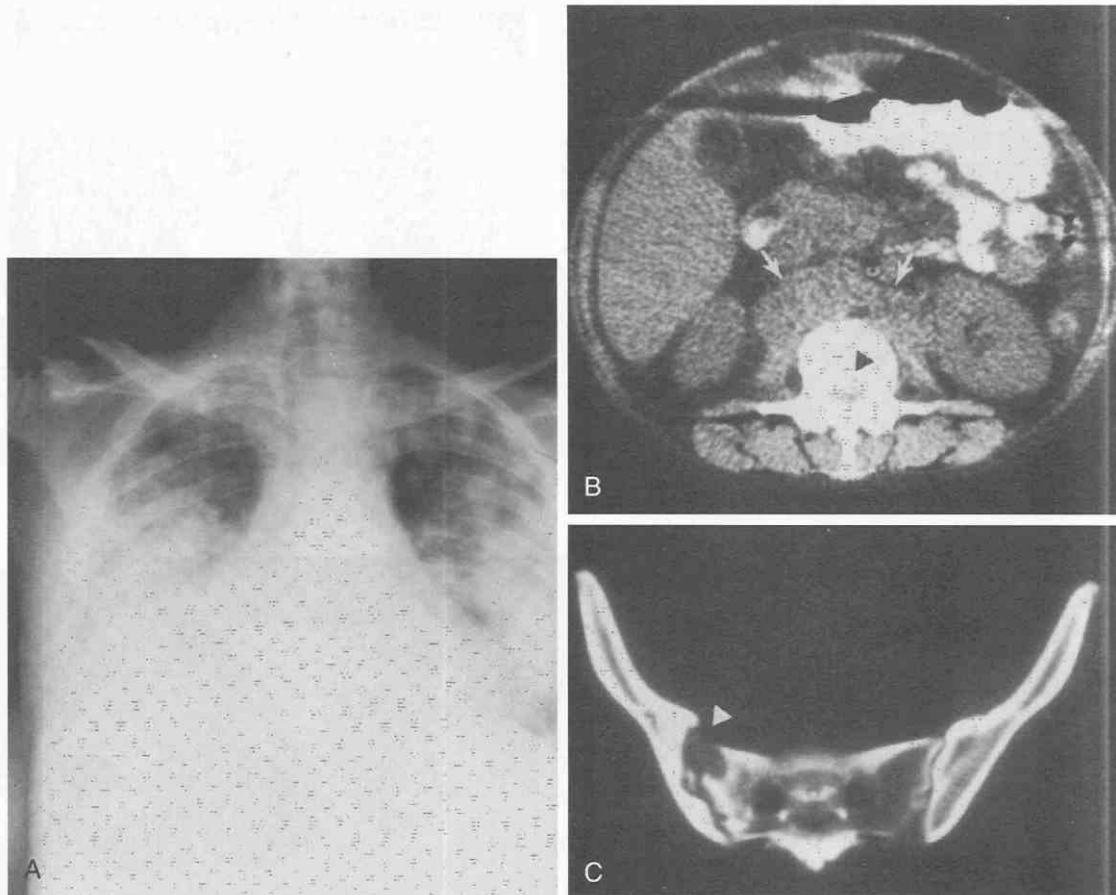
Tuberculosis in a patient with advanced acquired immunodeficiency syndrome (AIDS). A woman with status positive for human immunodeficiency virus (HIV) infection was shown at autopsy to have bilateral pulmonary infiltrates (A), extensive lymphadenopathy (B, arrows), and multiple lytic bone lesions (B and C, arrowheads) caused by widely disseminated tuberculosis. (From Kuhlman JE: AIDS-related diseases of the chest. In Kuhlman JE [ed]: CT of the Immunocompromised Host. New York, Churchill Livingstone, 1991.)
